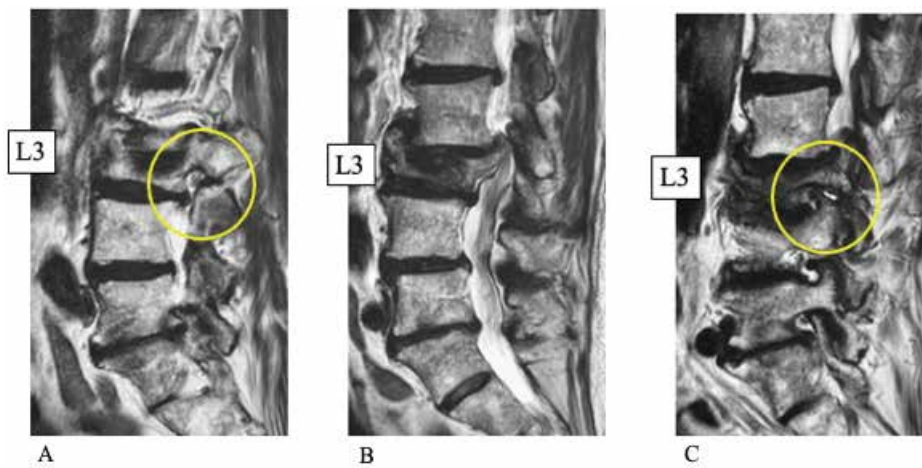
Preoperative T2-weighted magnetic resonance images. A : Right para-sagittal slice showing no foraminal stenosis at L3-L4 (yellow circle). B : Mid-sagittal slice showing spinal canal stenosis due to a posterior wall fracture of the L3 vertebral body. C : Left para-sagittal slice showing foraminal stenosis at L3-L4 due to the superior articular process of L4 and disc bulging at L3-L4 (yellow circle), which caused left L3 nerve root impingement.
